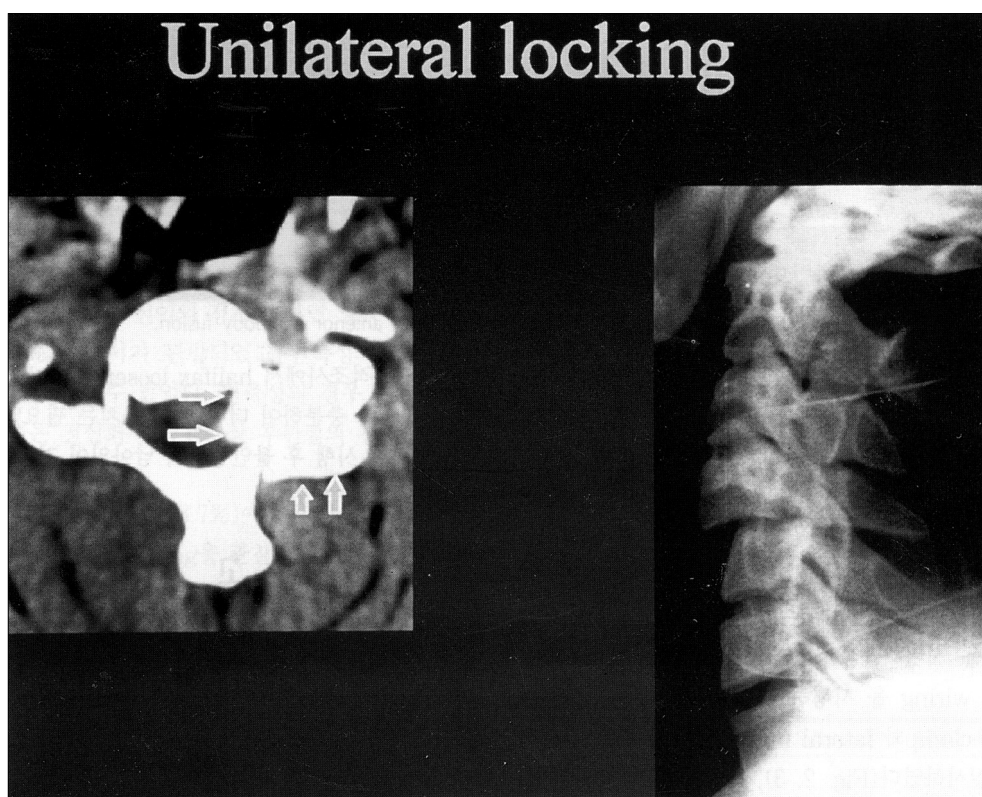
Unilateral interlocking at C4/5, CT scan shows narrowed lateral recess on the side of the lesion, causing radiculopathy.
